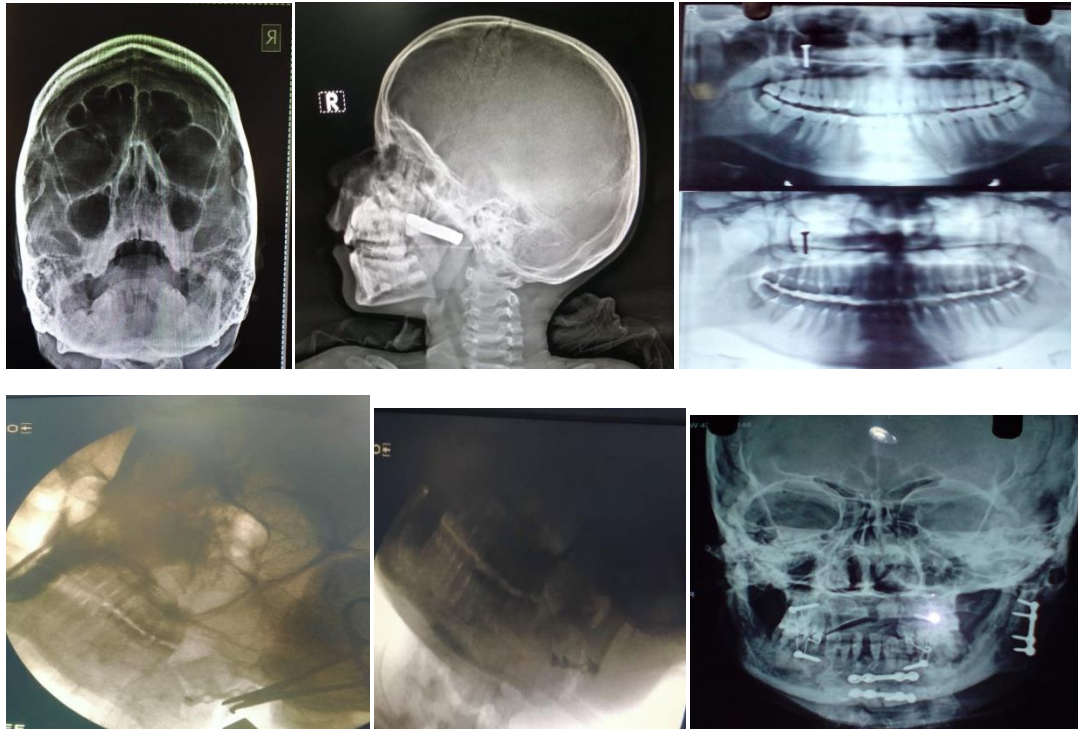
conventional radiography showing PNS, OPG, lateral oblique view of skull with gunshot injury
